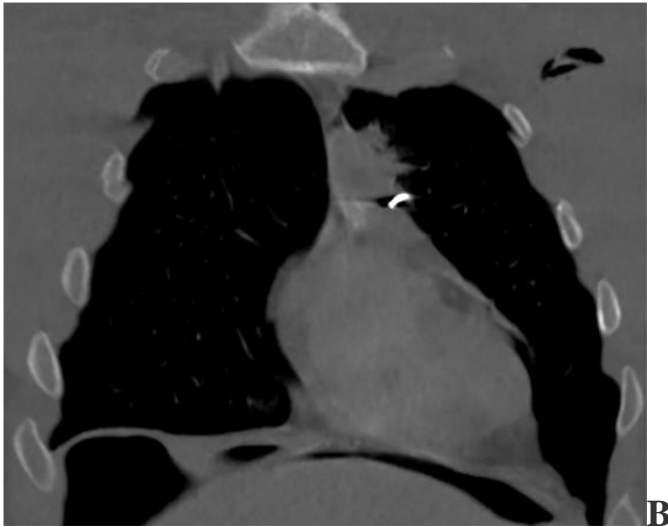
Spiral CT aortography: a metal fragment in the anterior mediastinum near the initial part of the pulmonary trunk. A – axial plane; B – coronary plane; B – sagittal plane.
